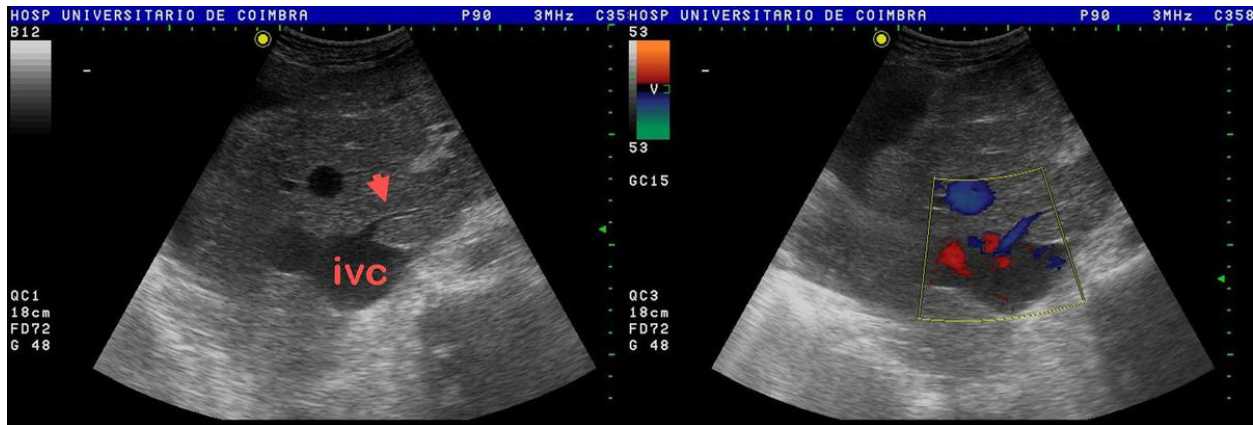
Ultrasound and Color Doppler images show hepatic vein draining the caudate lobe directly into the inferior vena cava.
